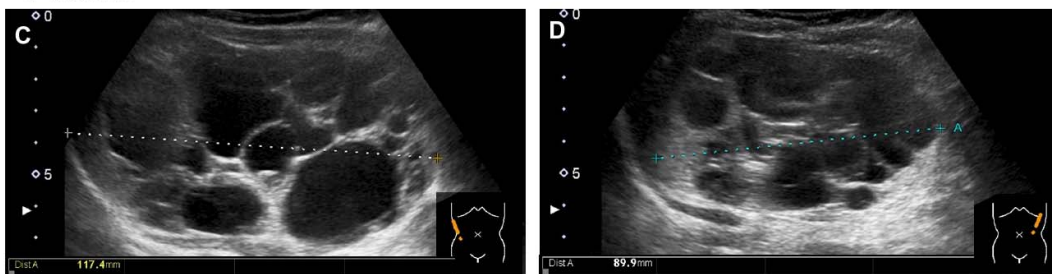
Ultrasonographic image of kidney A) B) at two months of age , C) D) at seven months of age
